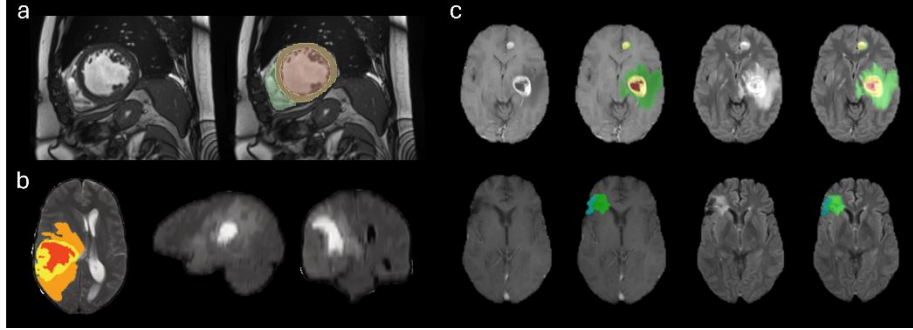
Representative MRI examples from each dataset used in this study. (a) Short-axis Steady-State Free Precession cardiac MRI from the ACDC dataset showing a raw acquisition (left) and the corresponding segmentation overlay (right) with left ventricle (pink), myocardium (tan), and right ventricle (green) delineations. (b) Axial FLAIR MRI views from the BraTS-Africa glioma dataset showing a large pre-operative tumour with enhancing tumour (ET, yellow), necrotic core (NETC, red) and peritumoral edema (SNFH, orange) overlaid on the FLAIR as well as hyperintensity extent visible in the sagittal and coronal views. (c) Two representative BraTS-METS cases shown on T1 post-contrast and FLAIR sequences. Top row: a pre-operative case with NETC (red), ET (yellow), and SNFH (green) annotations. Bottom row: a post-operative case demonstrating the resection cavity (RC, cyan) as an additional sub-region unique to post-treatment presentations.
